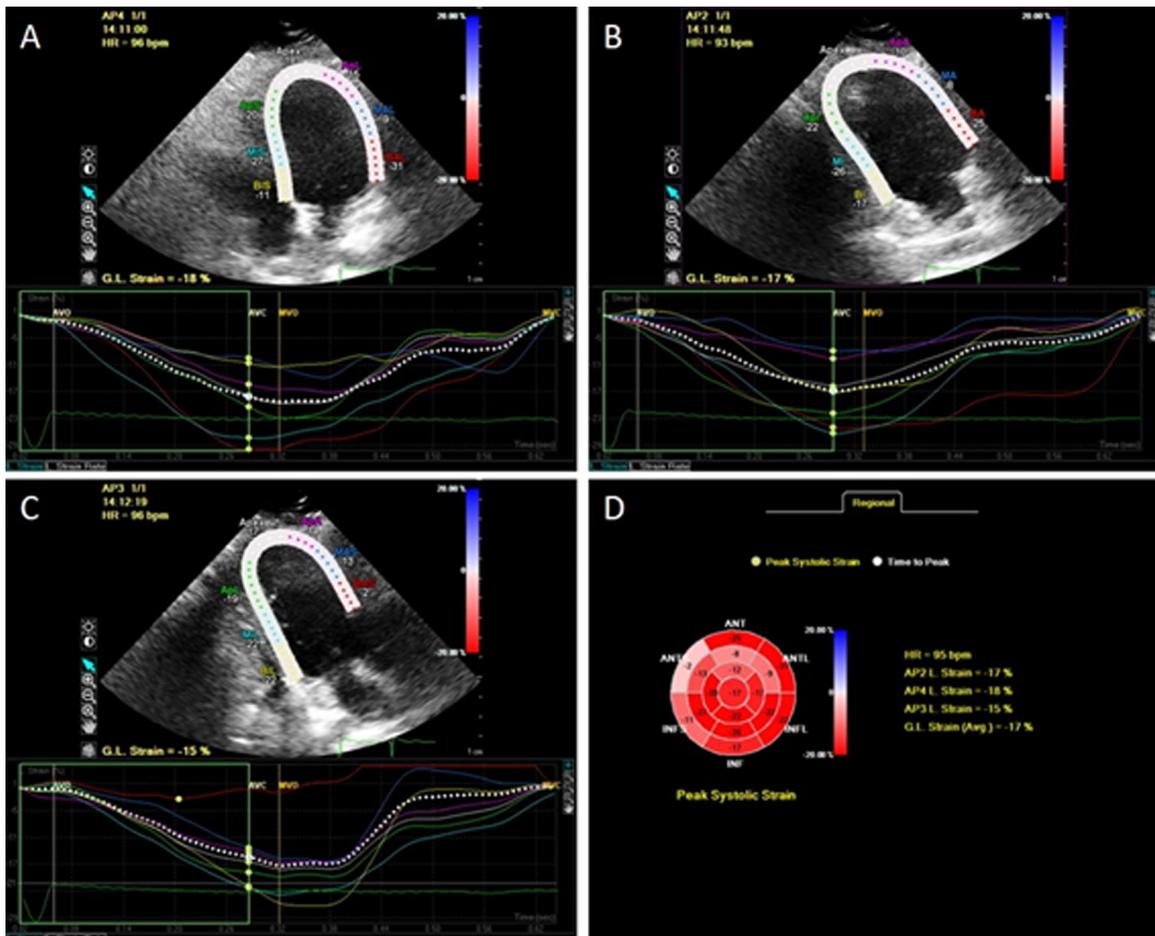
Measurement of the echocardiographic longitudinal strain in the apical incidences of four (A), two (B) and three (C) chambers, and the global longitudinal strain (D) in a DMD patient who showed early left ventricular systolic dysfunction (global longitudinal strain: -17%).
